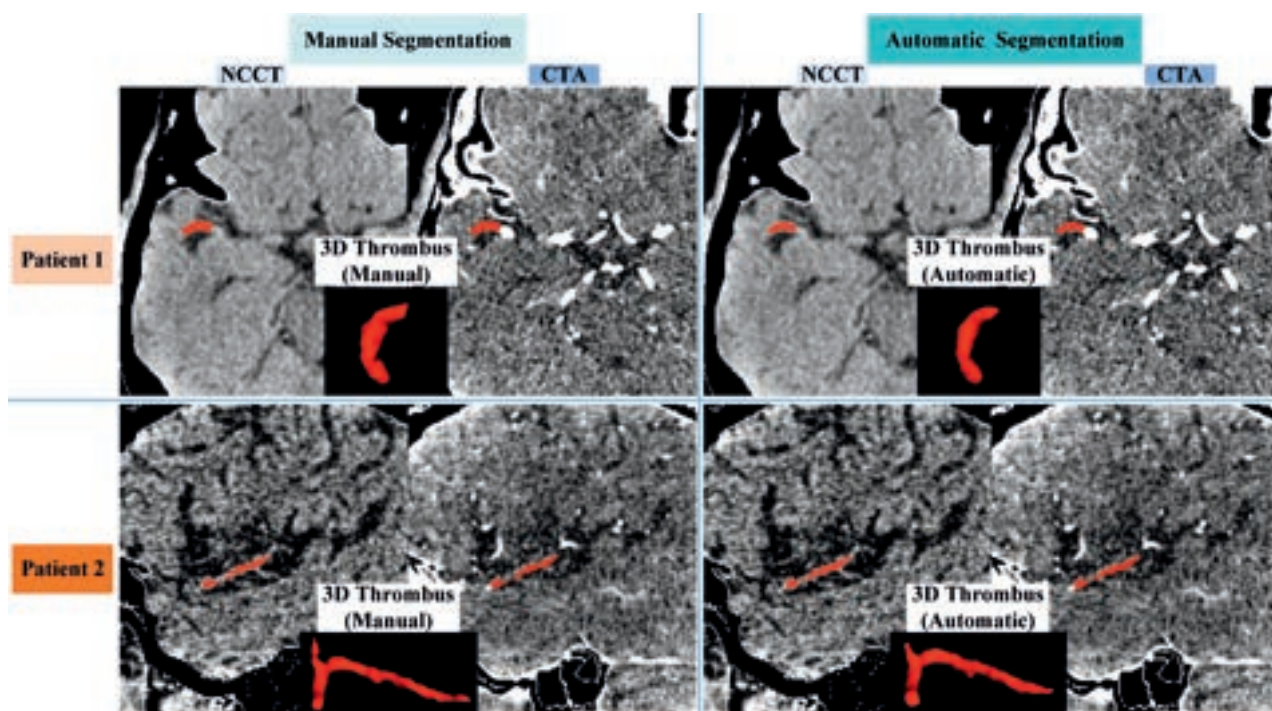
Two segmentation examples obtained by the proposed model. The images are shown as NCCT/CTA overlaid with the manually or algorithm-segmented thrombi in red.
